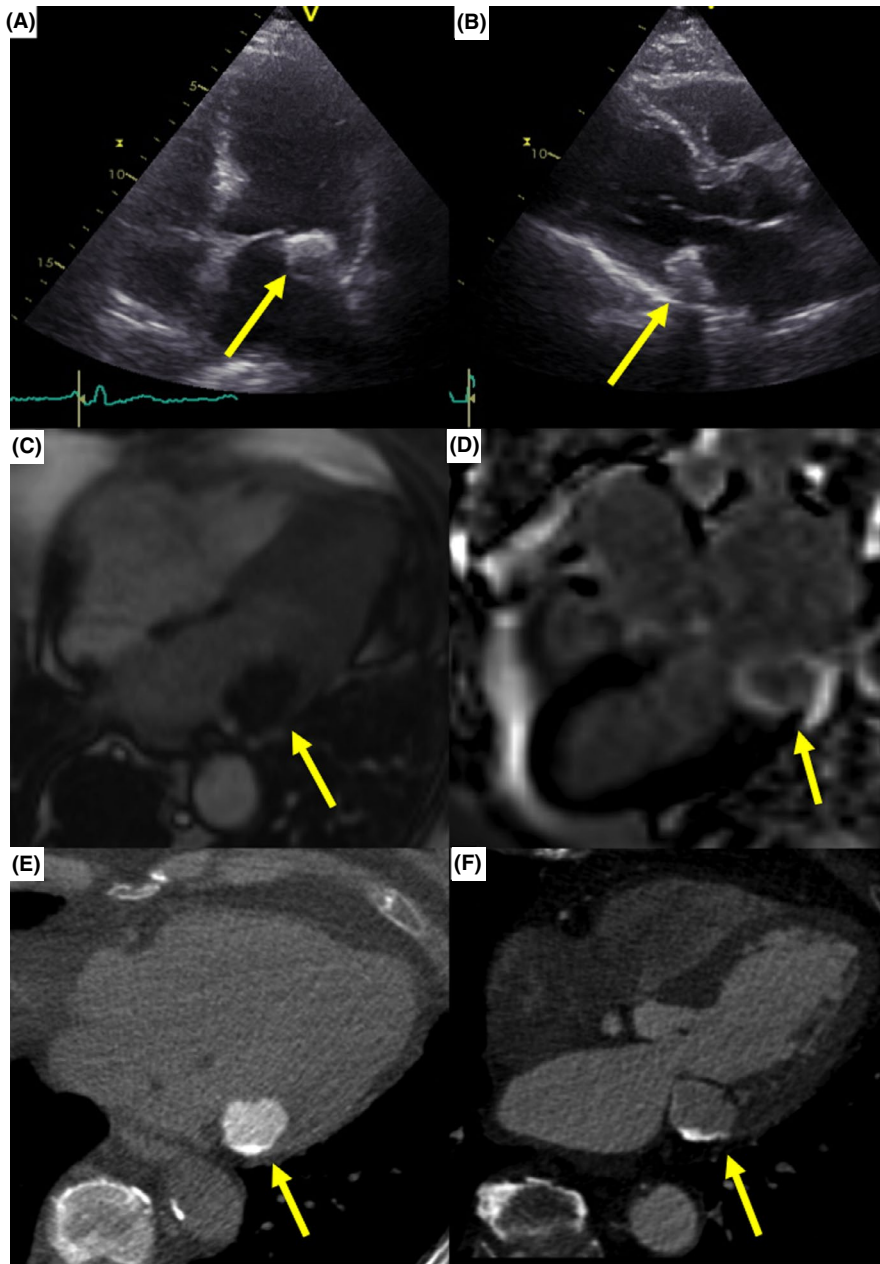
Transthoracic echocardiography revealed a hyperechoic mass adjacent to the posterior mitral valve leaflet (A, B). Cardiac MRI showed a semilunar mass with low signal intensities, most consistent with calcium (C). Delayed enhancement images showed peripheral rim enhancement (D) which may be confusing but is thought to reflect a fibrous cap. The central core showed no enhanced (D). CT showed a hyperdense mass in the area of the posterior mitral valve annulus with even denser peripheral calcifications. The central density within the mass (E) is thought to reflect caseous necrosis (E, unenhanced CT image; F, contrast-enhanced CT image)
